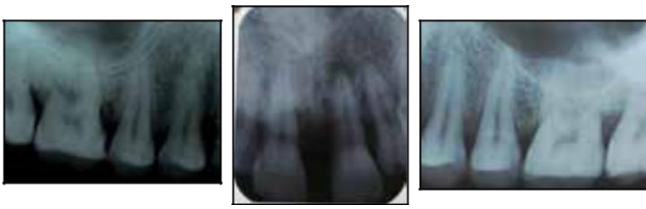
Orthopantomograph (OPG) and Intra Oral Peri apical Radiographs (IOPAs)
